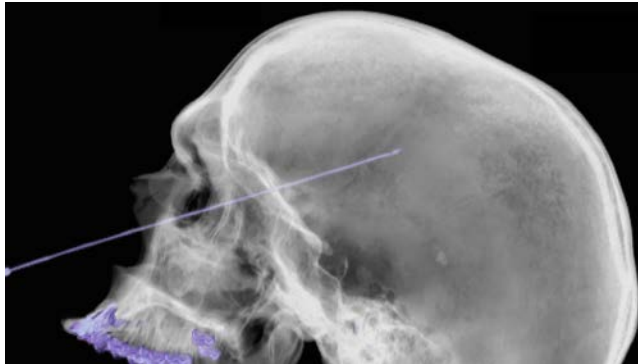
The skull presented with the osseous transparent metal mode of the console software (Siemens Healthineers Syngo CT 2014 A VB42B) of subject 9 represented in the sagittal with the temperature probe along the longitudinal fissure (Picture: C. Berger/Institute of Forensic Medicine).
